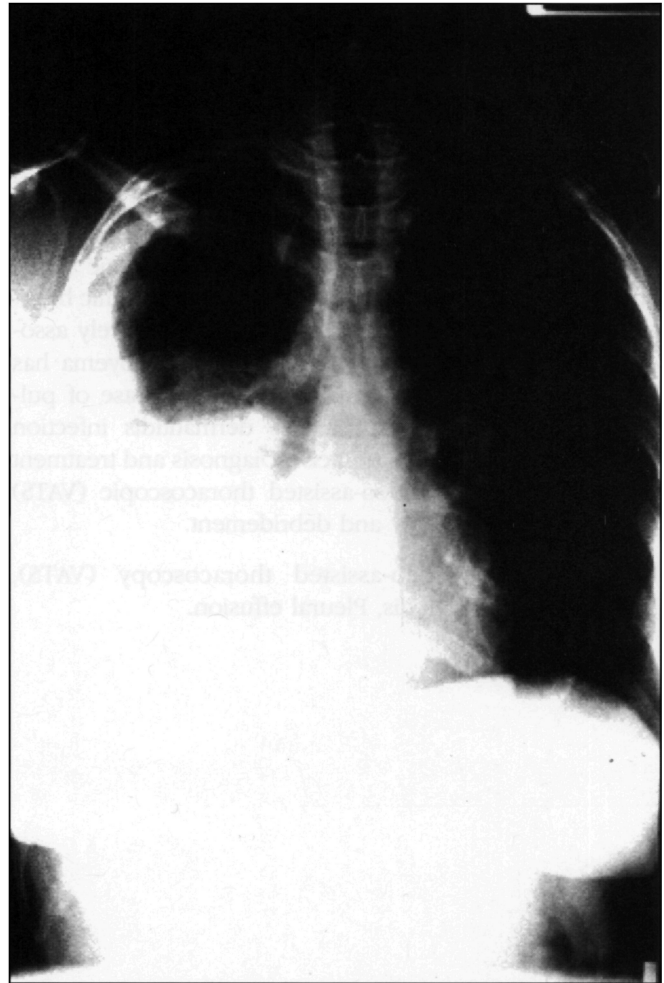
Chest radiograph (posterior/anterior) demonstrating right lower lobar atelectasis and a large pleural effusion.
